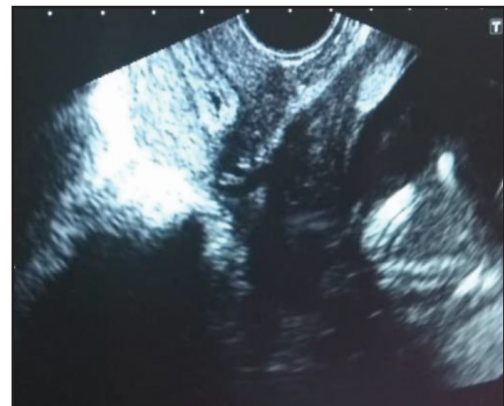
Ultrasound image showing empty uterine cavity at left upper corner and the extrauterine fetus in the right lower corner.
